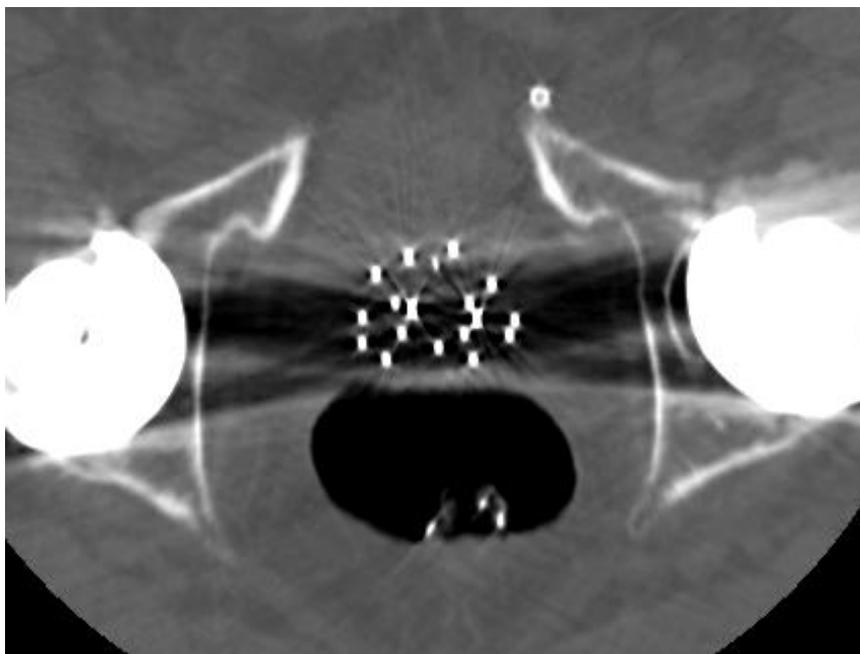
CT slice from 15th patient at SCGH (Toshiba Aquilion LB, 135 keV, 400 mAs. FOV 250x250 mm, 512x512 array, 16 bit grey-scale, 0.5 mm slice thickness, 'soft tissue' filter). Slice shows implanted needles, fiducial markers, and wire ribbon in rectal packing.
